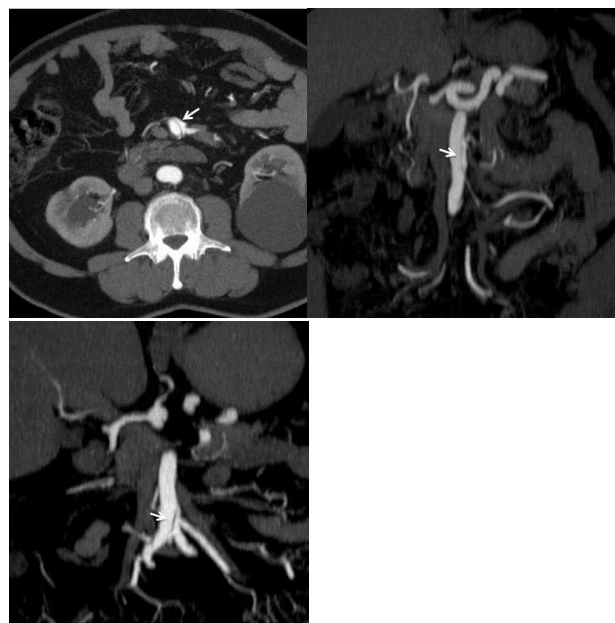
A 55-year-old woman with sudden onset abdominal pain. On axial (a) and coronal (b) MIP reconstruction CTA scans, a type IIa isolated SMA dissection is observed (arrow). After 10 months follow up, CTA (c) was performed, which showed decreased in extension of dissection (arrow).
